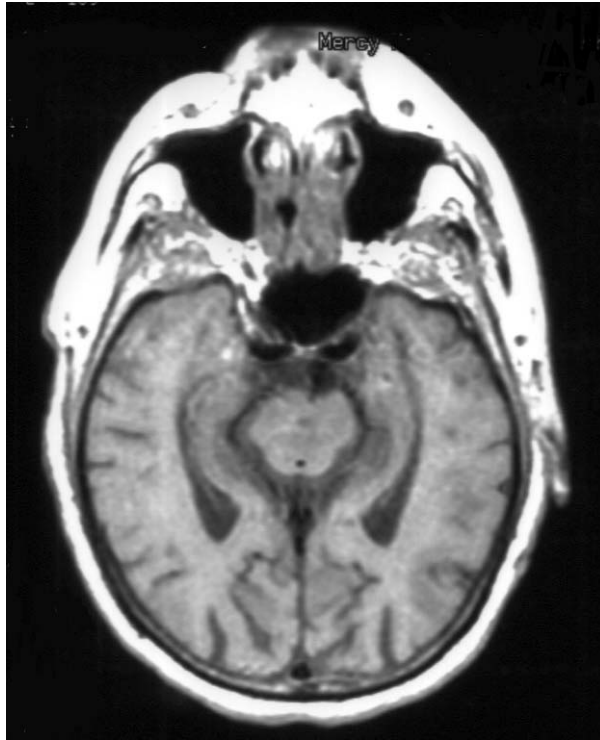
Magnetic resonance image of the head with contrast showed no contrast enhancing lesions within the meninges or brain parenchyma. (TR:683, TE:16)
